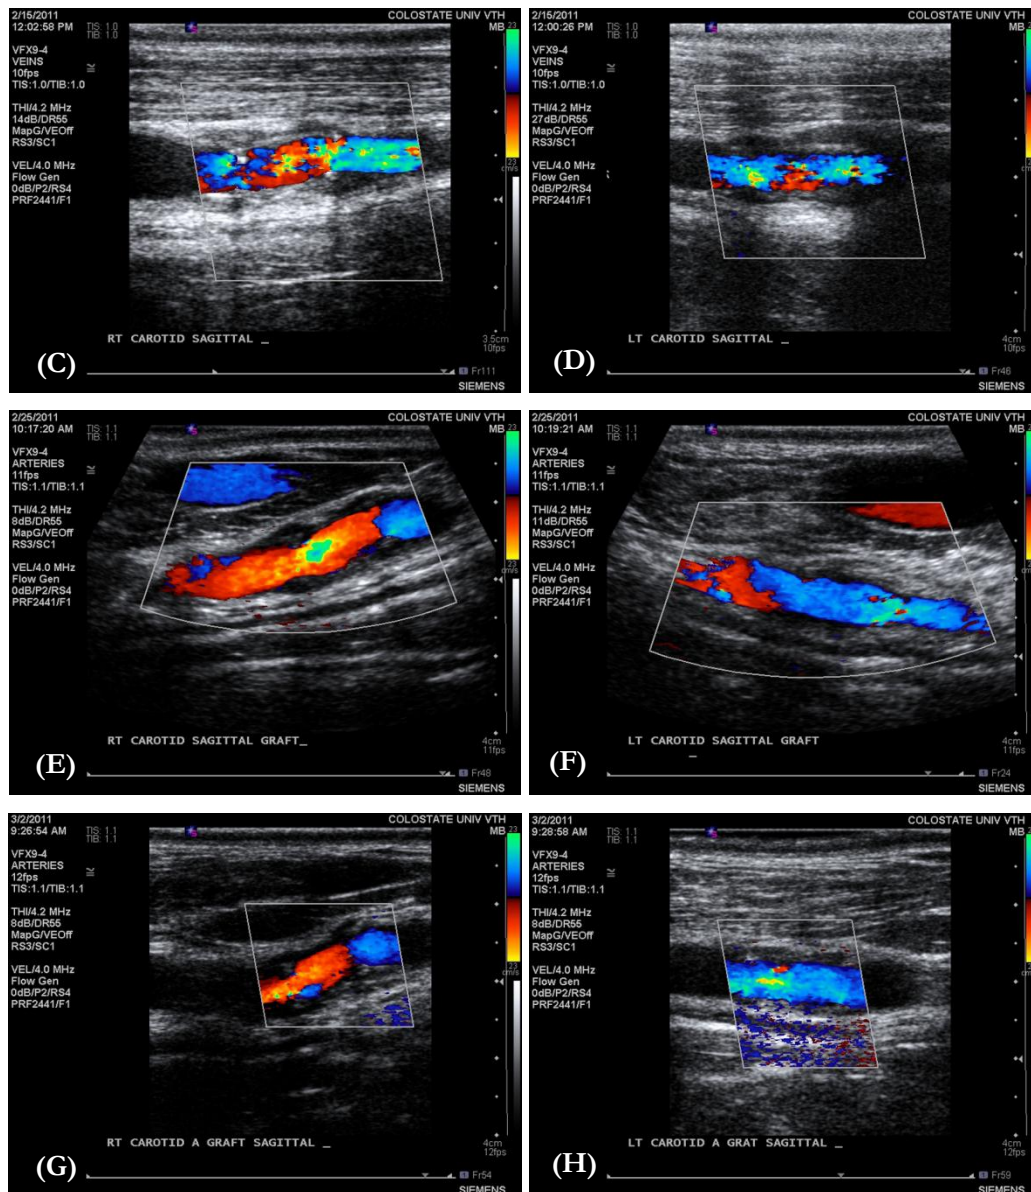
Ultrasound Sonography: (A): 1st Week Image of the graft on Right Carotid Artery; (B): 1st Week Image of the graft on Left Carotid Artery; (C): 2nd Week Image of the graft on Right Carotid Artery; (D): 2nd Week Image of the graft on Left Carotid Artery; (E): 3rd Week Image of the graft on Right Carotid Artery; (F): 3rd Week Image of the graft on Left Carotid Artery; (G): 4th Week Image of the graft on Right Carotid Artery; (H): 4th Week Image of the graft on Left Carotid Artery. (Note: Figures (A) & (B) are on the previous page)
